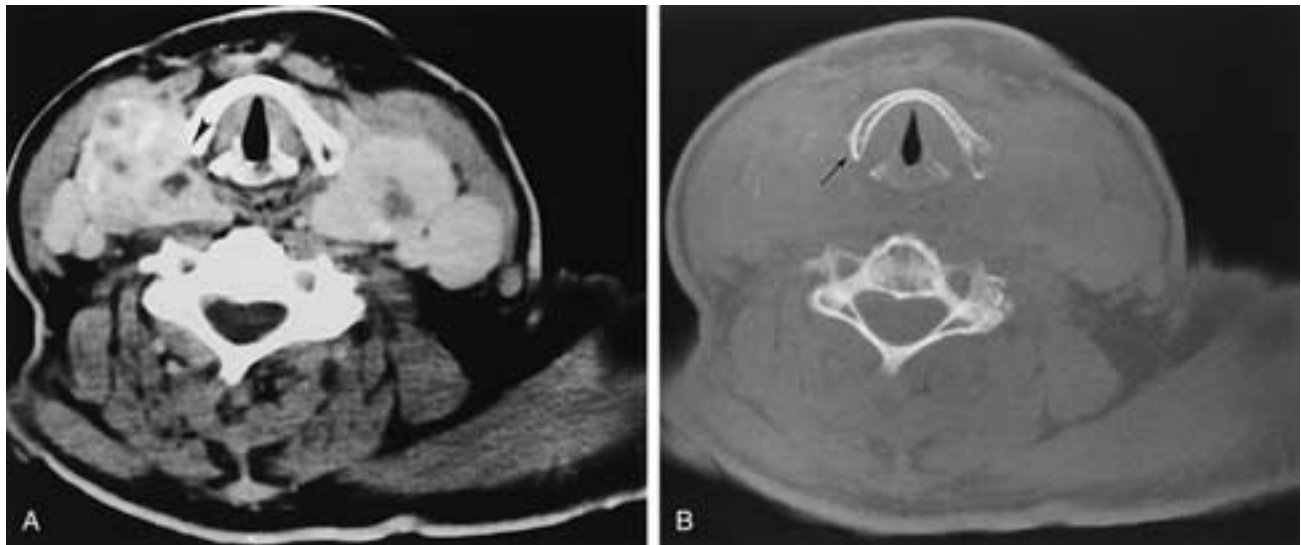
Axial CT. A, Large multinodular goiter causing shortening and remodeling of the lateral aspect of the thyroid ala (*arrowhead*). B, Bone algorithm showing the intact cortical line of the remodeled cartilage (*arrow*).
